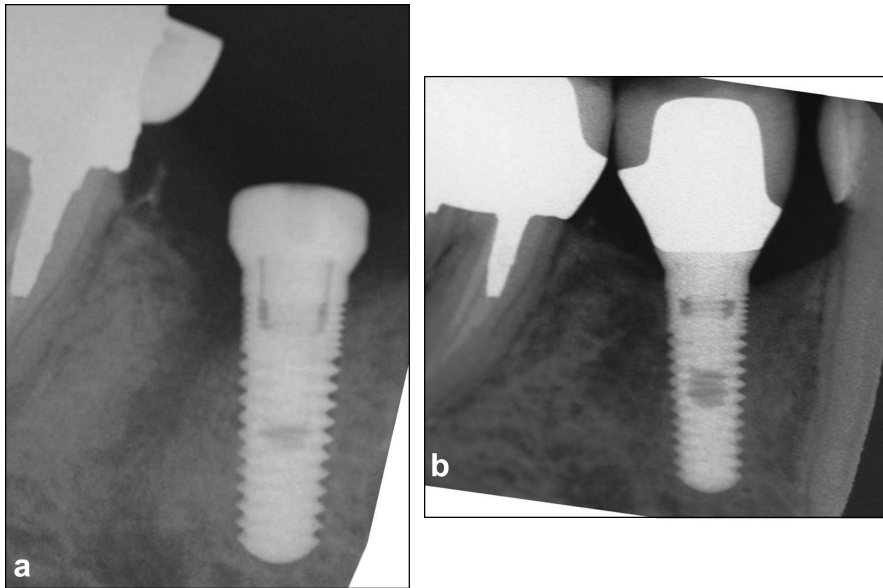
a, Radiograph taken at implant insertion providing a baseline measurement of proximal bone levels. b, Radiograph taken at 12 months after implant insertion which is also 6 months after restoration of the implant. Note that the proximal bone changes are limited to the nonthreaded, blasted portion, or the junction of the nonthreaded portion and the microthreaded portion of the implant.
